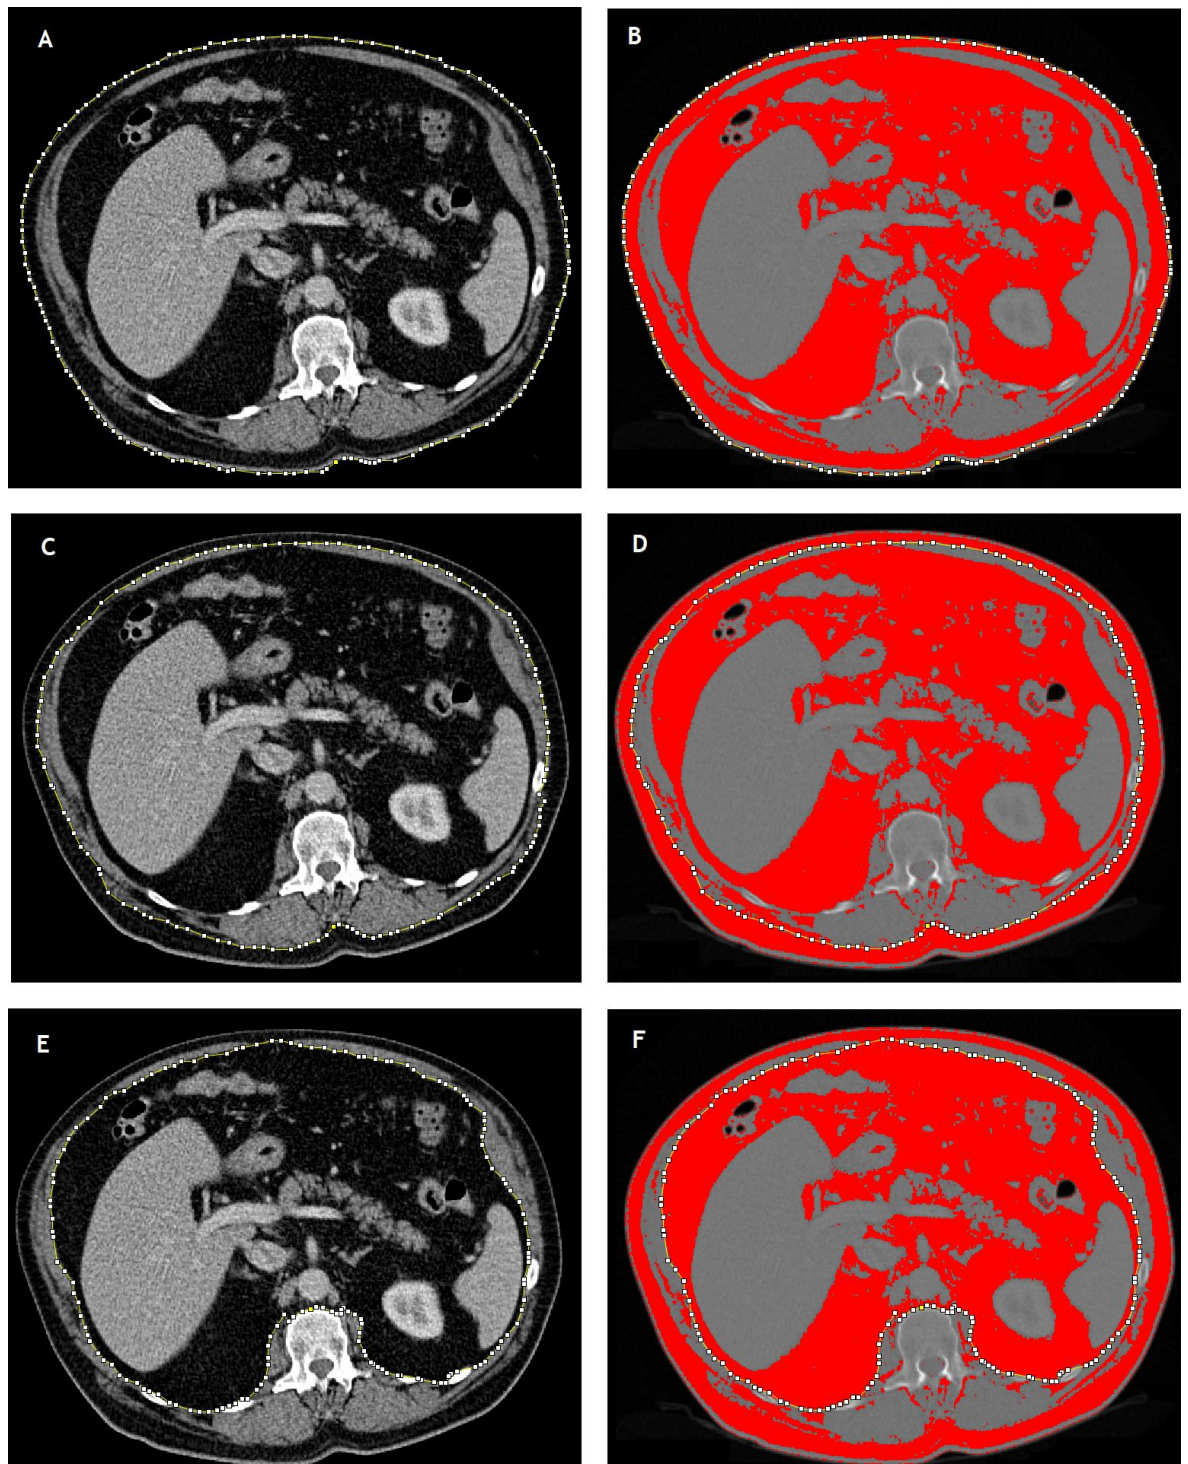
Axial slices of CT scans demonstrating L3. Panel A demonstrates the delineation of the external adipose tissue on ImageJ software, defined by the area included in the dotted yellow line. Panel B demonstrates the adipose tissue threshold selection using established adipose tissue HU ranges of -190 to -30 HU. Panel C demonstrates the delineation of external adipose tissue area. Panel D demonstrates adipose tissue HU threshold selection. Panel E and F demonstrates internal adipose tissue area (defined by the area included in the dotted yellow line) and HU threshold selection, respectively
